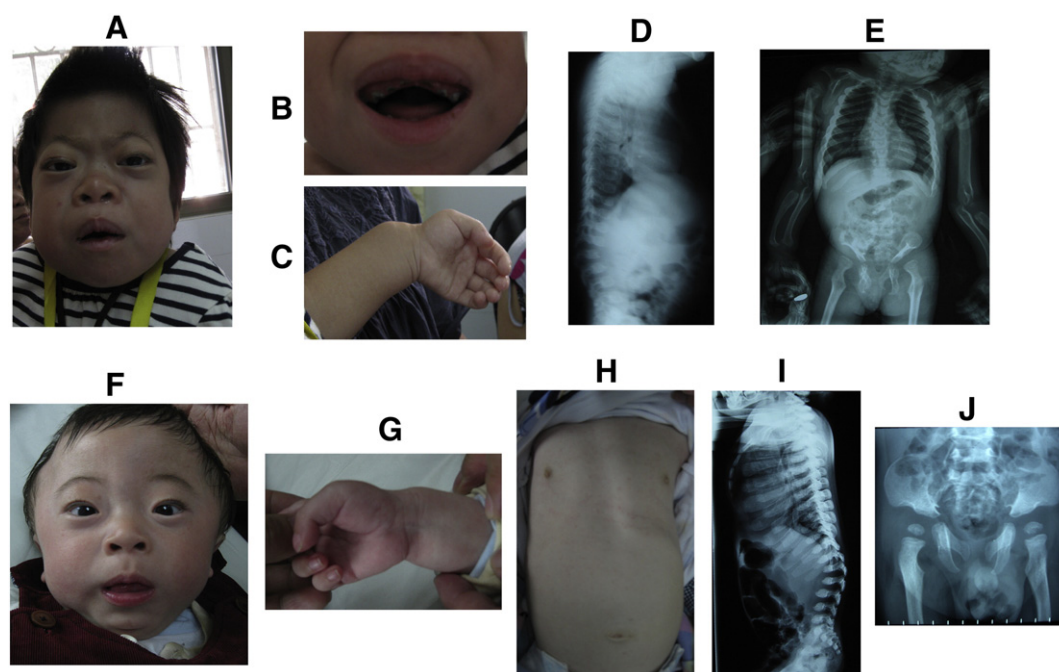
Clinical features of the two Chinese patients with ML II alpha/beta. For Patient 1: (A–B) A “coarse” face was noted with a low nasal bridge, inner epicanthic folds, gum hypertrophy, and partially erupted teeth. (C) Patient 1 had broad wrists bilaterally. (D–E) Radiographs of Patient 1 showed multiple dysostosis including generalized osteopenia, oar-shaped ribs, and scoliosis. For Patient 2: (F) He had noted “coarsening” of face with narrow forehead, thin eyebrows, low nasal bridge, long philtrum, open mouth. (G–H) Patient 2 also had broadening of wrists and fingers, a deformed chest. (I–J) Dysostosis multiplex (short, thick clavicles, thick elevated scapula with poorly formed glenoid fossa, oar-shaped ribs, and scoliosis) in Patient 2.
